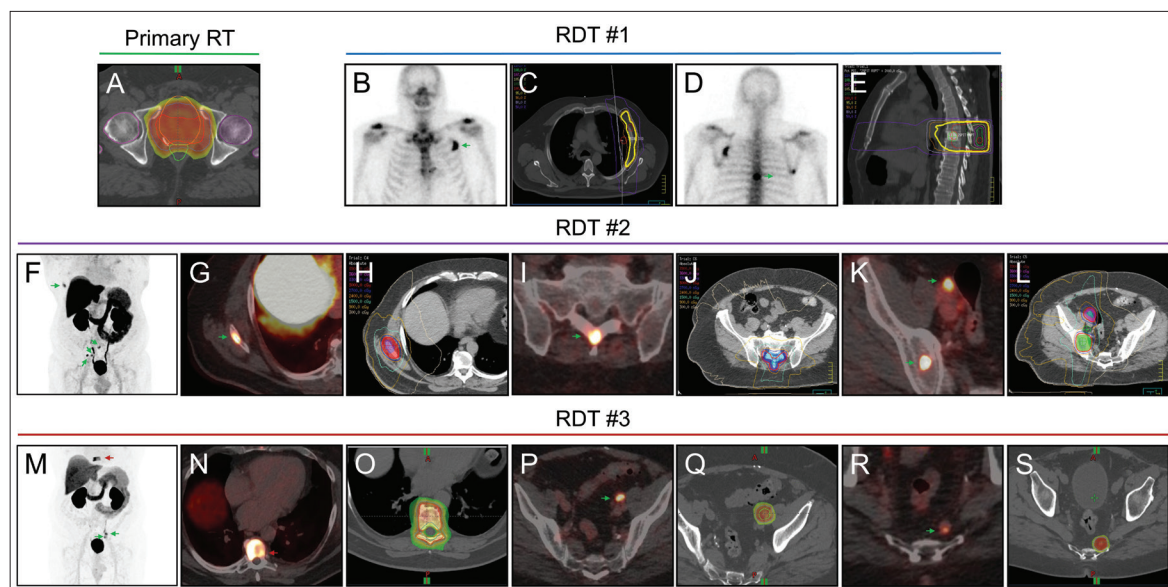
Imaging and radiotherapy (RT) plans for primary and metastatic prostate cancer. (A) Radiation plan for prostate bed treated in 2014. (B, D) Bone scan in June 2018 revealed metastatic foci in the third rib and T7 spine (green arrows). (C, E) Three-dimensional conformal radiation plans (2000 cGy in 5 fractions) for metastases in the T7 spine and third rib. (F) Prostate-specific membrane antigen positron emission tomography (PSMA-PET) scan in January 2020 showed complete response in previous metastases but identified several new sites (green arrows from top to bottom): Right scapula (G), sacrum (I), two right external iliac lymph nodes (one shown) and right ilium (K). Stereotactic body radiotherapy (SBRT) plans (3000 cGy in 5 fractions) for the metastatic sites at (H) right scapula, (J) sacrum, and (L) one of the right external iliac nodes and right ilium. (M) PSMA-PET scan in June 2022 showed disease recurrence at the T7 vertebra (red arrow; N), plus novel sites in the right external iliac lymph node (top green arrow; P) and perirectal lymph node (bottom green arrow; R). SBRT plans (3000 cGy in 5 fractions) for the re-treatment of T7 spine (O) and the treatment of the right external iliac lymph node (P) and perirectal lymph node (S).
